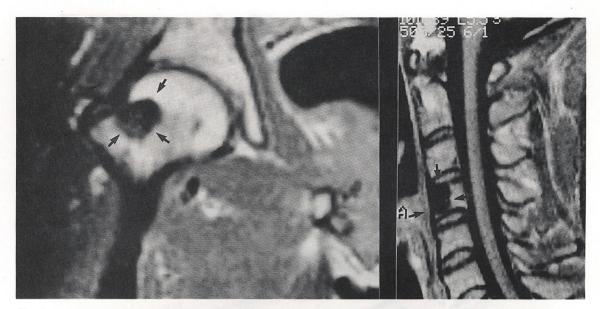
Coronal and sagittal T1-weighted (TR/TE = 700/25 and 500/25) images of the right femur neck and cervical spin demonstrate well-defined, low signal intensity arease indicating osteosolerotic myelomatous lesions (arrow).
